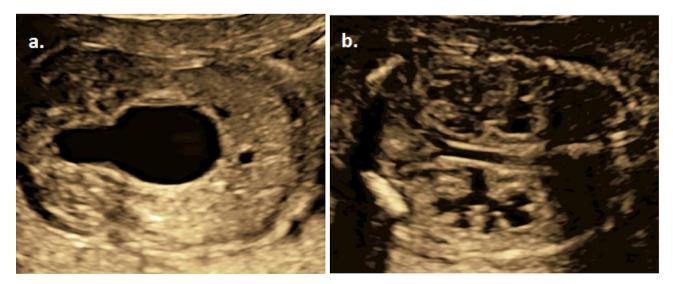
Ultrasound images before fetal surgery showing the typical "keyhole" bladder at 19 weeks 3 days gestation (a) and bilateral pelvicalyceal dilatation with hyperechoic renal cortex (b)
